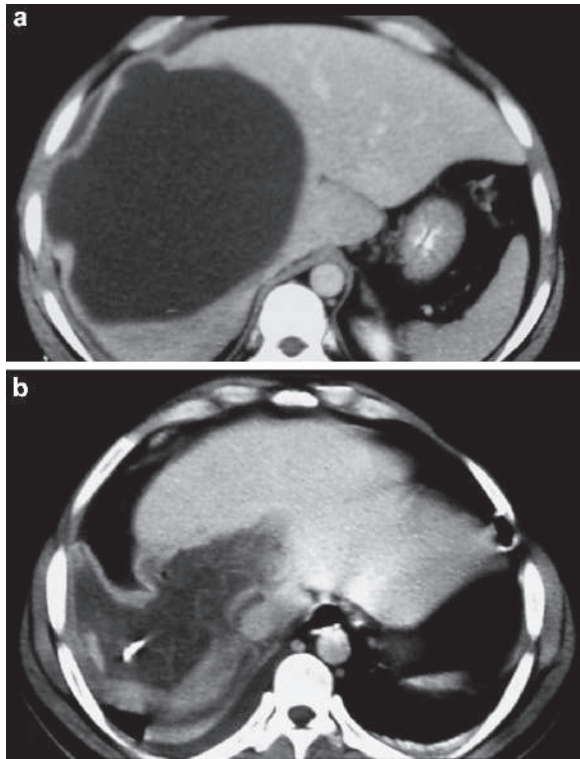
Axial abdominal CT images show a very large hydatid cyst that occupies almost the entire right lobe of the liver (a), and the cyst appearance after aspiration of the cyst contents (b)
